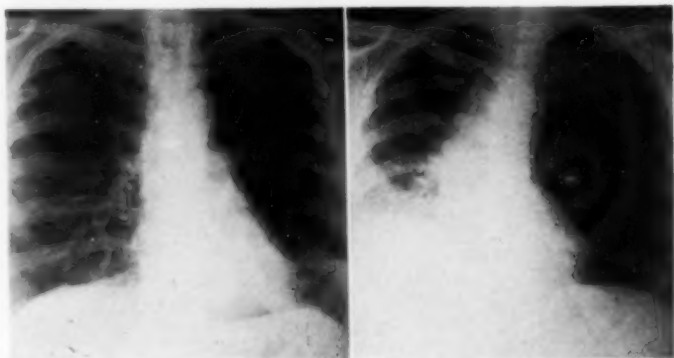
Roentgenograms showing obstructive emphysema of left lung, due to adenoma of cylindroma type causing check-valve obstruction of left main bronchus. Film to the left shows inspiration, film to the right, expiration.
